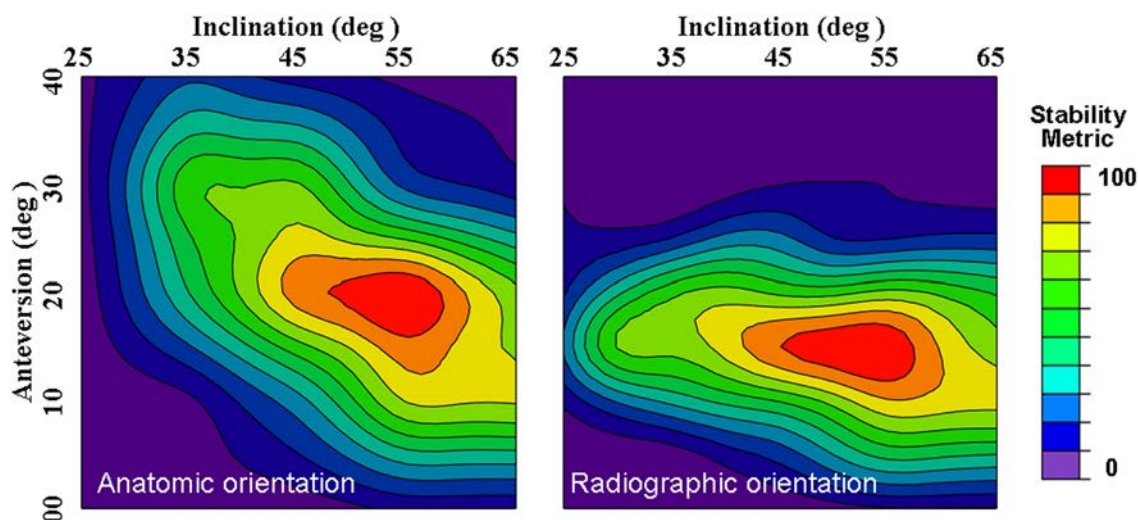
From the averaged head subluxation, a “stability metric” was computed in anatomic orientation (left), which was then interpolated into the radiographic reference frame (right). The stability metric is a normalized parameter (1-100). The instance shown is that for a 36mm femoral head with 20° femoral anteversion.
